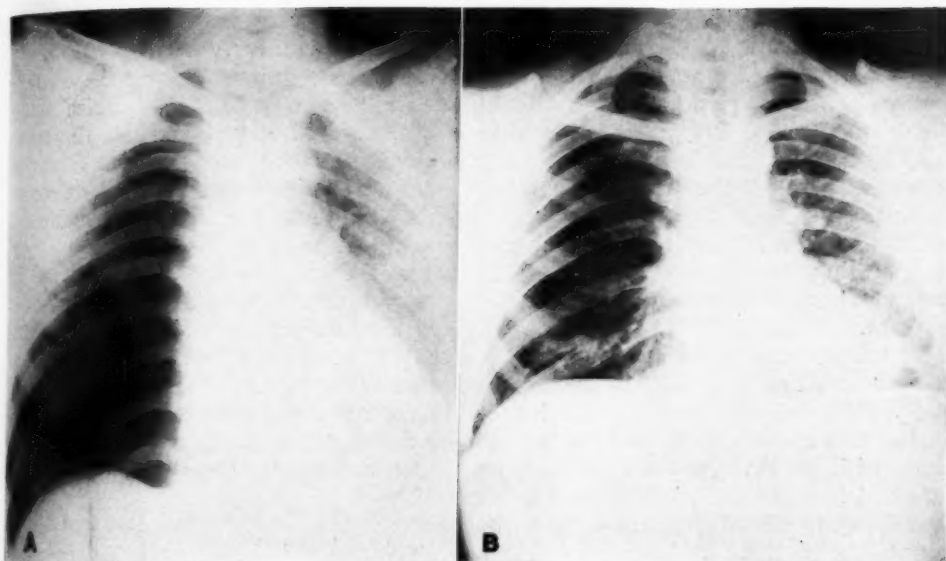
Simple spontaneous pneumothorax treated as a case of pulmonary tuberculosis. A. Spontaneous pneumothorax, right, tension type, with left lateral mediastinal displacement, March 28, 1940. B. Roentgenogram of chest on April 18, 1940, following five aspirations for relief of dyspnea, disclosing over 75 per cent re-expansion of right lung. No evidence of tuberculosis.
